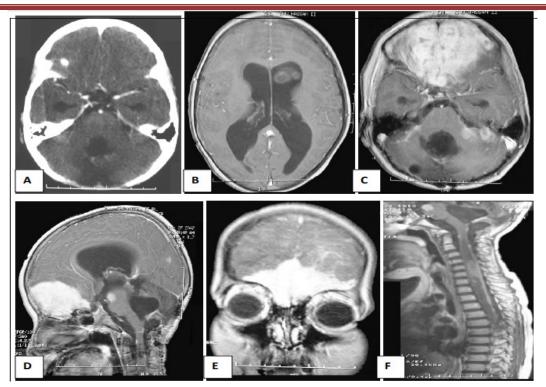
showing an injected contrast CT scan just some few days post operative. Figure B, C, D, E, and F: MRI of the same patient 4 months post operative showing disseminated craniospinal metastasis.
